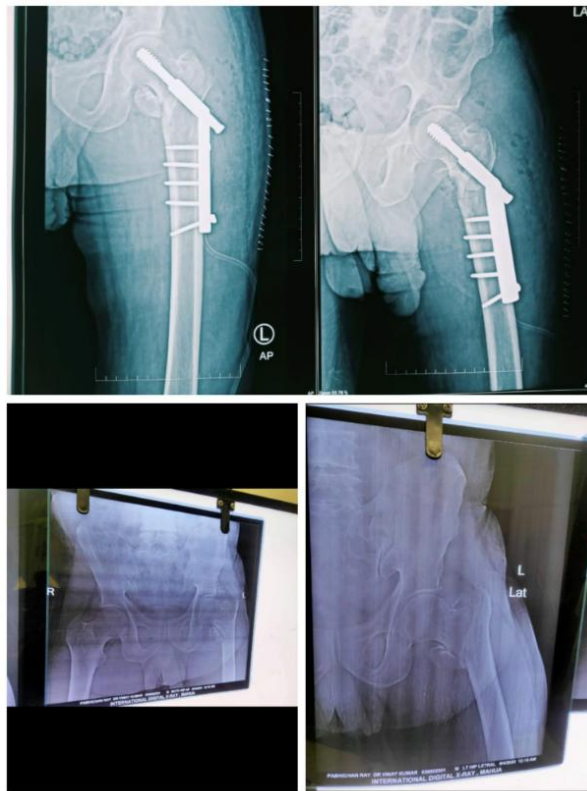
12-week and 24-week follow-up radiographs of DHS.
